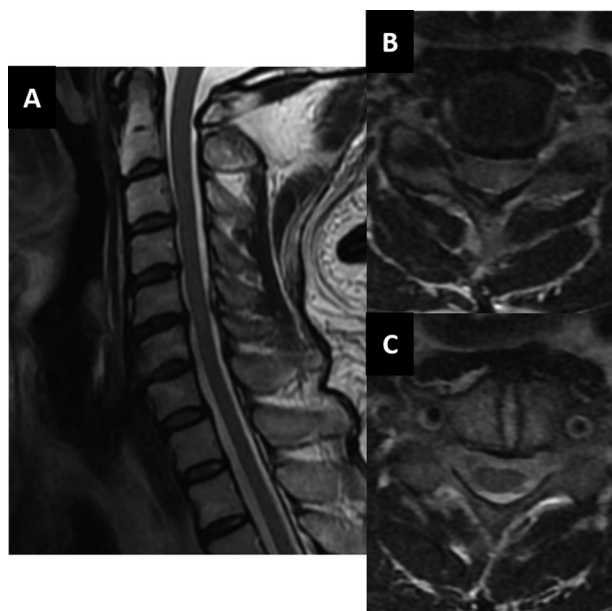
MRI of the cervical spine on the day after the operation. T2-weighted images of the sagittal (A) and axial (B: C5-6 level; C: C6 level) views show an intramedullary signal intensity at the C5-6 disc level, into which the K-wire had penetrated, but no hematoma or spinal fluid leakage was observed.
